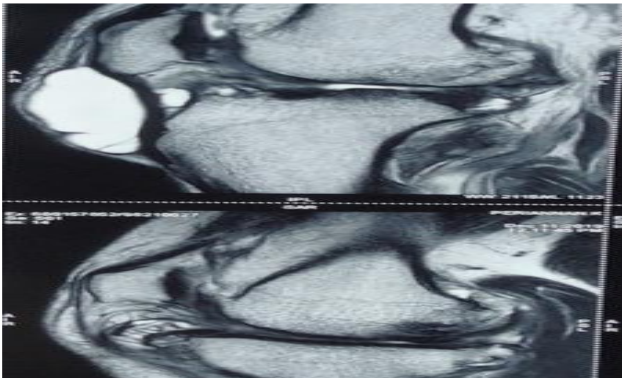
Saggital FS MRI images.
